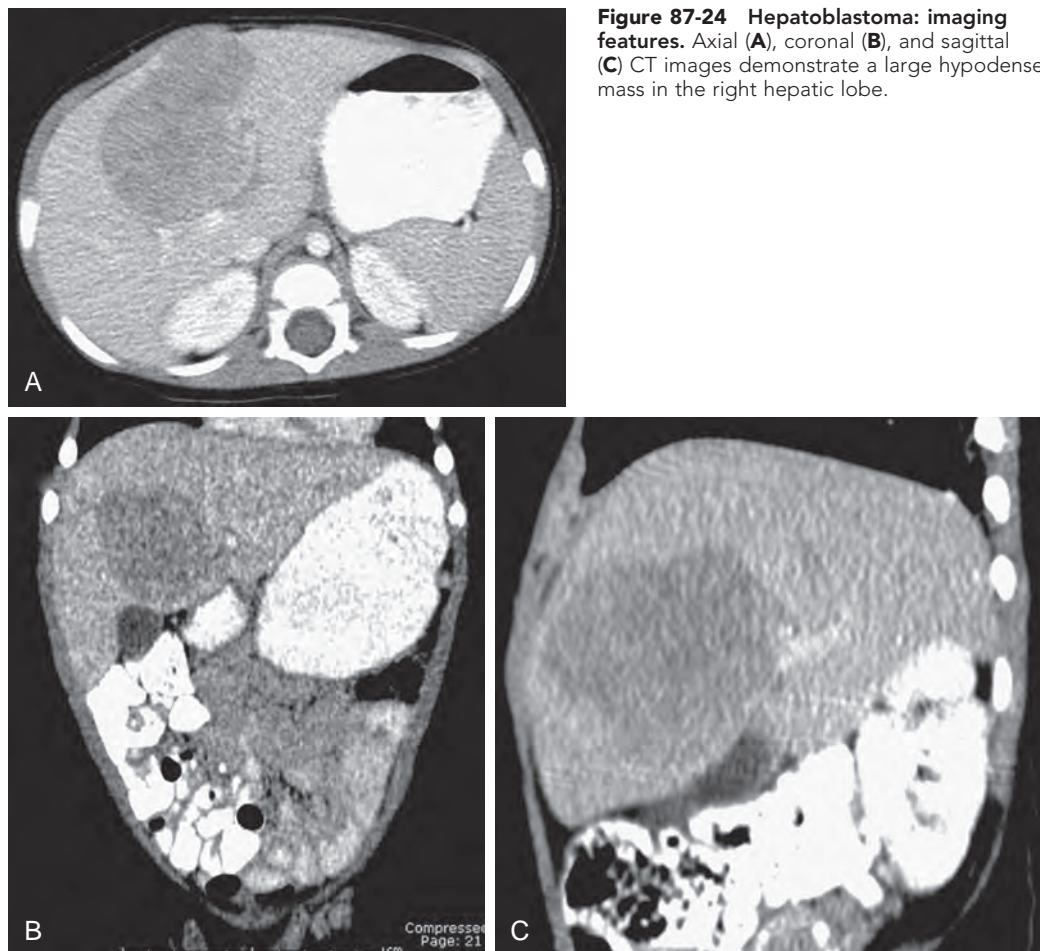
Hepatoblastoma: imaging features. Axial (A), coronal (B), and sagittal (C) CT images demonstrate a large hypodense mass in the right hepatic lobe.
